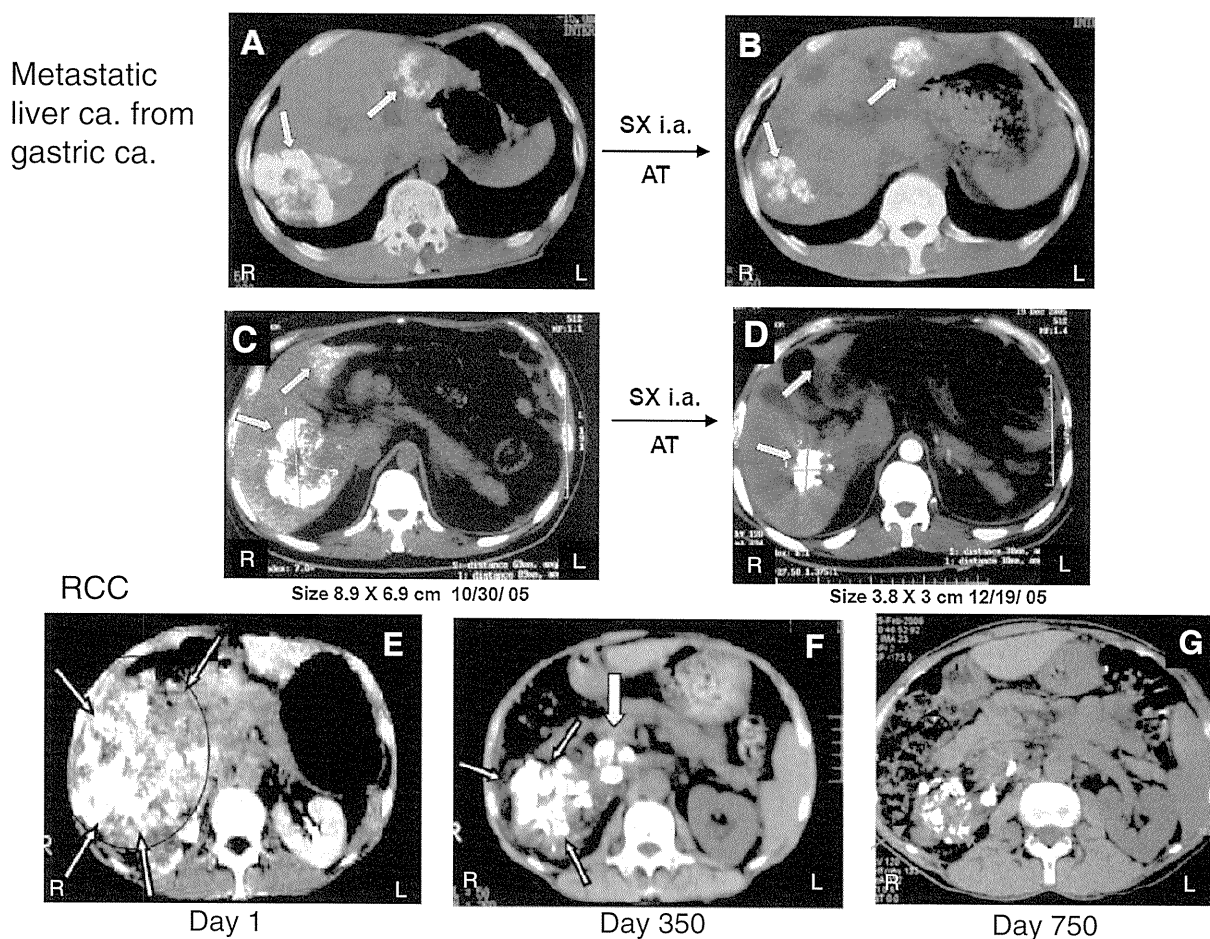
CT scan images of (A) and (C) show stomach cancer metastasized to the liver. They received SX/LP(SMANCS/Lipiodol) i.a. under AT-II-induced hypertension, at about 150–160 mmHg. The notable reduction to about 10% of the original volume of tumor was observed in 1–2 months (see B,D) (Adapted from ref. 88)). In the bottom three CT images showing a case of massive renal carcinoma. SX/LP was administered via the renal artery under AT-II-induced hypertension. CT scans at left was taken at day 1, middle at day 350, and on lower right at day 750 showing remarkable regression. Also please note a metastatic tumor nodule at the inferior vena cava (middle; large white arrow). This metastatic tumor (nodule) regressed to a small spot in the scan at day 750 (right). Dose of SX/LP administration was 3–4 mg in about 2 ml at a time, and the patient received total of 14 times i.a. infusion in three years. This patient is still alive after 9 years with good QOL.
